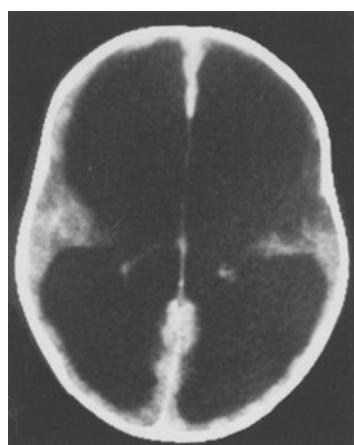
CT scan of a 9-month-old child who presented with hydrocephalus secondary to tuberculous meningitis. There is extreme ventricular dilatation and periventricular edema. Also, an area of necrosis of the brain parenchyma due to tuberculous encephalitis can be seen in the left parietal region
